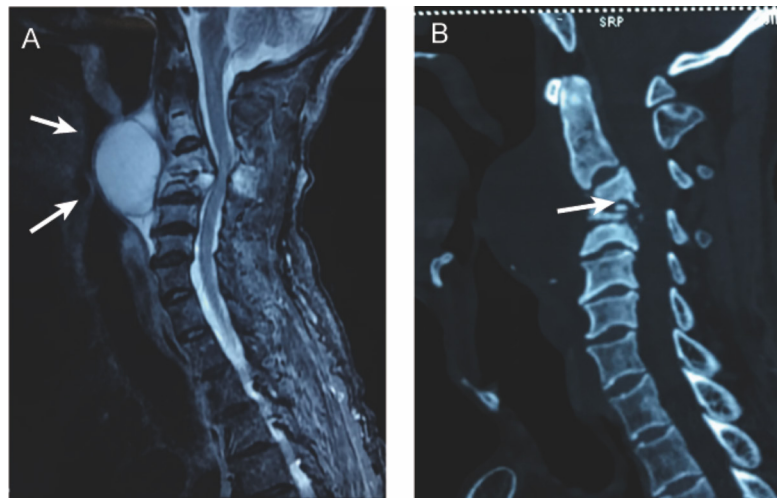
MRI and CT scans of the cervical spine before treatment. A, Massive anterior vertebral mass, trachea and esophagus compression, and vertebral body destruction (MRI). B, Vertebral collapse, narrowing of the intervertebral space, and C3C4 vertebral destruction (CT scans).
